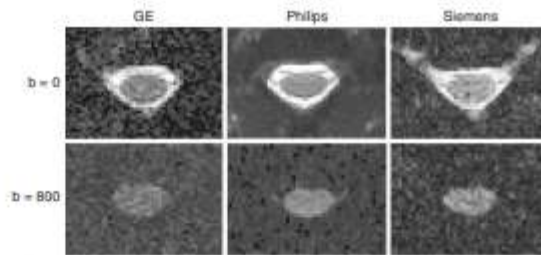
Axial views of good-quality data for DWI scans at $b = 0 \text{ s/mm}^2$ (top row) and $b = 800 \text{ s/mm}^2$ (bottom row). The DW image corresponds to a diffusion gradient vector fairly orthogonal to the cord axis, hence the visible spinal cord. Notice the different noise patterns across the manufacturers, which is due to the different types of filters applied across manufacturers; these filters were present in an older version of the protocol, but have been removed in the latest version of the protocol in order to minimize differences across manufacturers.
